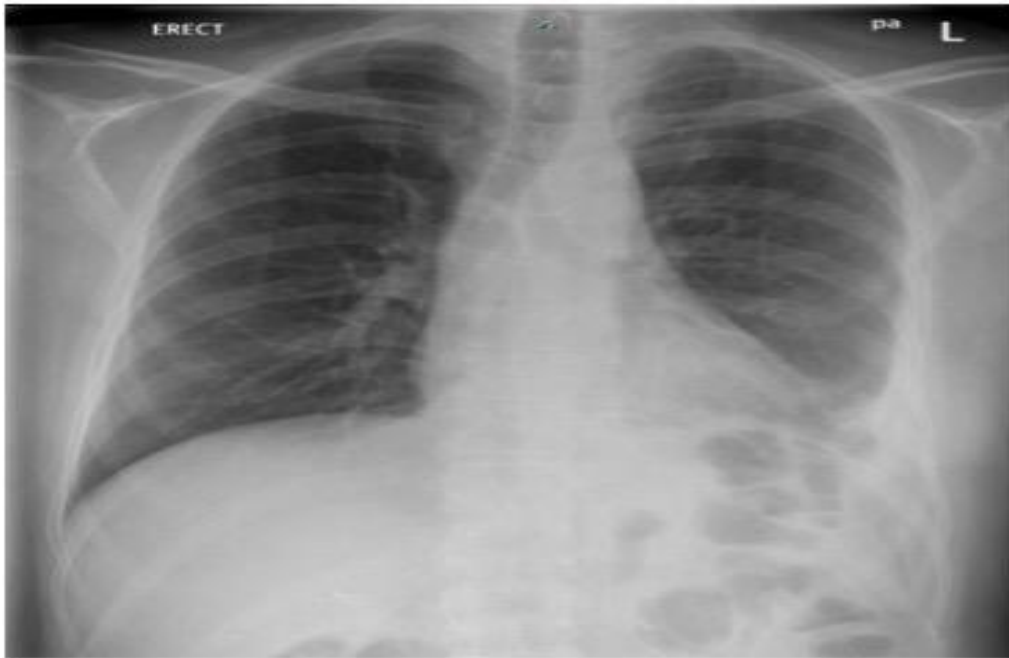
Chest X-ray showed left costophrenic angle blunting
